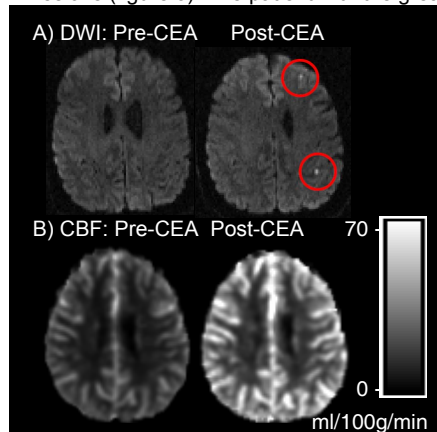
A) DWI and B) CBF images before and after surgery for a patient that developed a DWI infarct subsequent to surgery. DWI infarcts circled in red. CBF images are displayed with the same scale.
